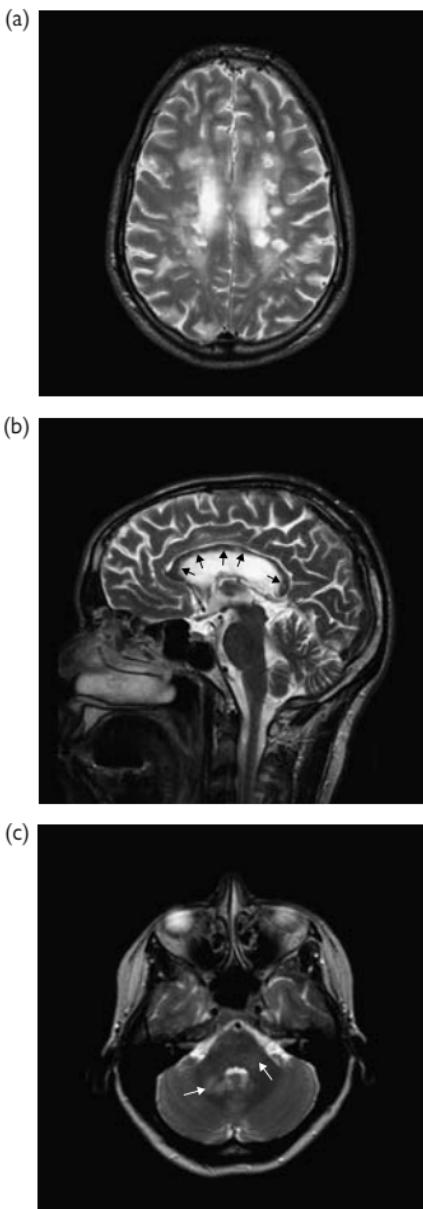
Multiple sclerosis. (a), (c) T2-weighted axial; (b) sagittal T2-weighted MRI. Multiple rounded or ovoid deep cerebral white matter lesions with surrounding areas of ill defined less pronounced hyperintensity are typical. There is marked involvement of the corpus callosum demonstrated axially and sagittally (black arrows). Involvement of the posterior fossa is common, in this case, lesions in the middle cerebellar peduncles are particularly suggestive of MS (c white arrows.) (a), (b) Note that there is loss of white matter volume and thinning of the corpus callosum in keeping with the latter stages of disease progression.
